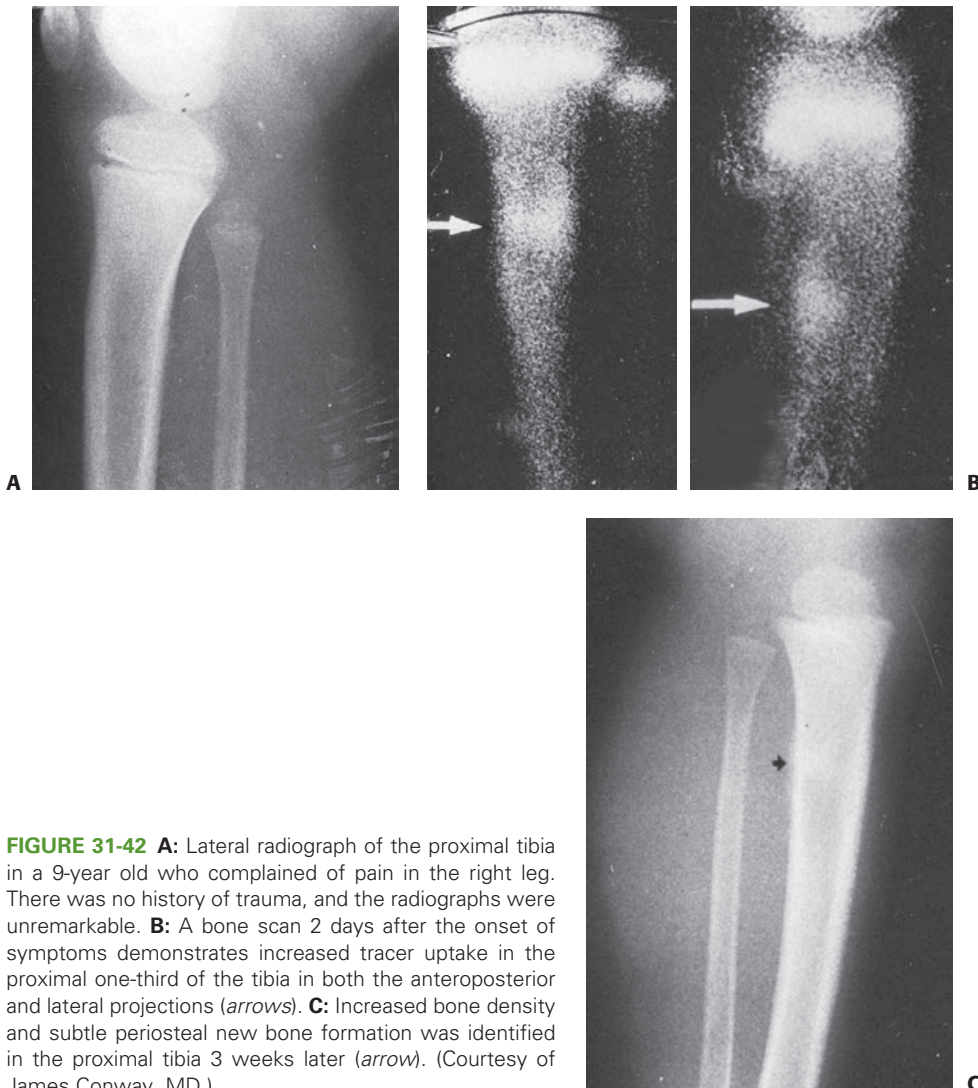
A: Lateral radiograph of the proximal tibia in a 9-year old who complained of pain in the right leg. There was no history of trauma, and the radiographs were unremarkable. B: A bone scan 2 days after the onset of symptoms demonstrates increased tracer uptake in the proximal one-third of the tibia in both the anteroposterior and lateral projections (*arrows*). C: Increased bone density and subtle periosteal new bone formation was identified in the proximal tibia 3 weeks later (*arrow*). (Courtesy of James Conway, MD.)
